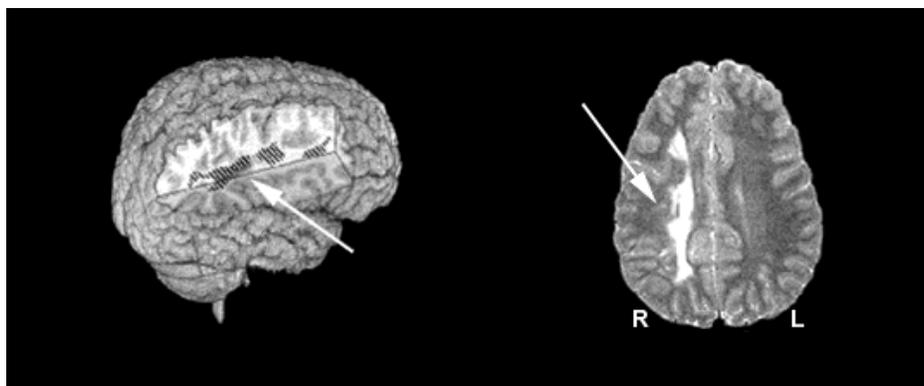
Lateral and axial MRI views of M.-RH showing the location and extent of his brain lesion (adapted with permission from Moses et al., 2000a).
